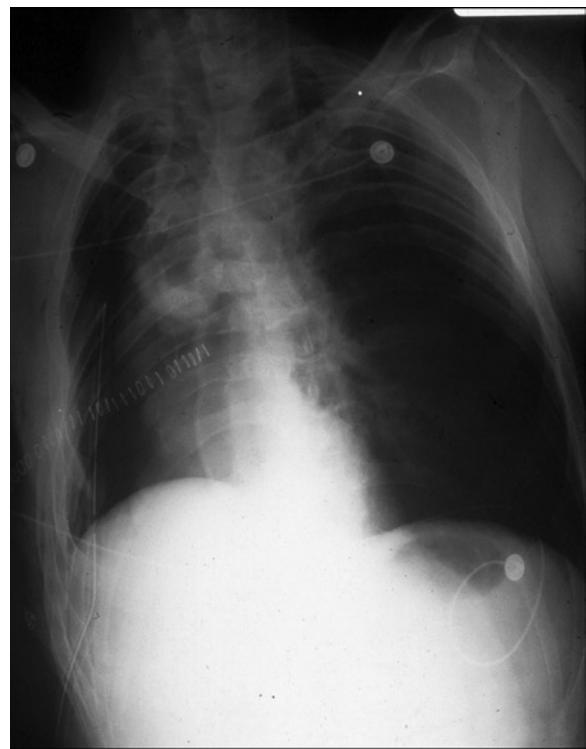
Immediate postoperative chest X-ray of a 55-year-old male following a right pneumonectomy. This is normal postpneumonectomy film.
